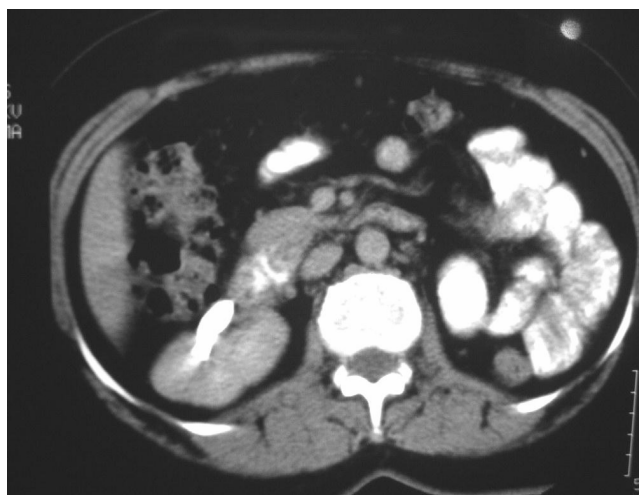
Abdominopelvic CT scan showing a malrotated right kidney and left kidney is not seen in left upper quadrant.
